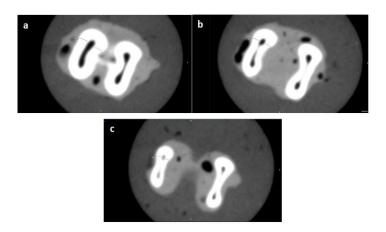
Axial CBCT images of the distal root canal at coronal (a), middle (b), and apical (c); showing the measured dentin thickness at the level of minimum dentin thickness.
